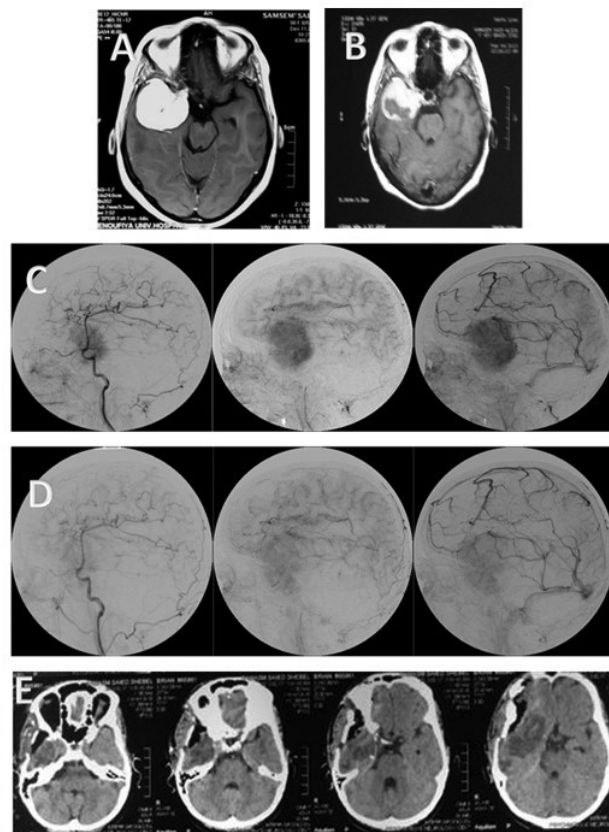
A case with right sphenoid wing meningioma A) Pre-embolization MRI axial T1 with contrast shows homogenous tumor enhancement, B) Post-embolization MRI axial T1 with contrast shows tumor necrosis and shrinkage with capsular enhancement, C) Pre-embolization ECA angiogram in different phases shows tumor blush, D) Post-embolization ECA angiogram in different phases shows disappearance of tumor blush, E) Post-operative axial CT brain shows total tumor resection.
